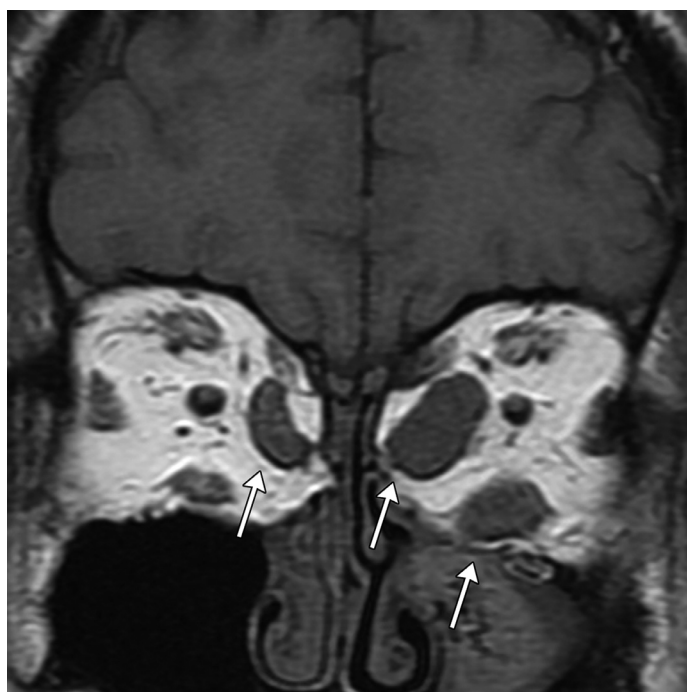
Advanced Graves disease with thyroid ophthalmopathy. Coronal T1-weighted MR image of the orbits shows enlargement of extraocular muscles (arrows) as well as increase of the intraorbital fatty tissue.
